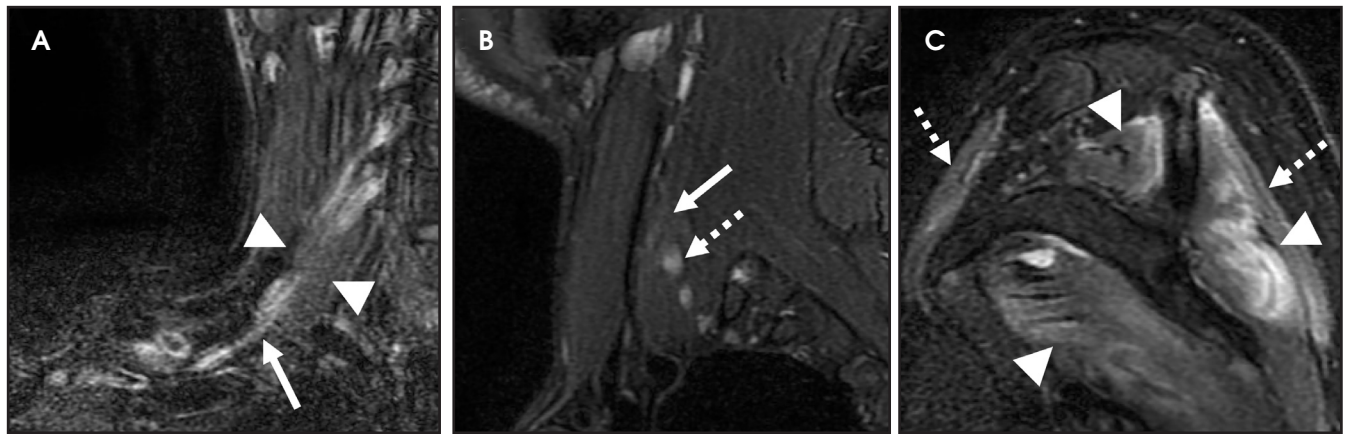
Brachial plexus traumatic postganglionic avulsions in a 39-year-old man following a motorcycle accident. Coronal T2W, fat-saturated MRI (A) of the right brachial plexus shows apparent discontinuity of the postganglionic C5 and C6 nerve roots (between the arrowheads). There is extensive downstream edema within the upper trunk of the right brachial plexus (solid arrow). On sagittal T2W, fat-saturated MRI sequences (B-medial and C-lateral at the shoulder girdle) there is an absence of the C5 nerve root at the expected position compatible with complete avulsion (solid arrow in B), with diffuse enlargement of the C6 nerve root, likely due to severe stretching (dashed arrow in B). Associated denervation edema and atrophy of the right shoulder girdle musculature, including the rotator cuff muscles (arrowheads in C) and deltoid muscle (dashed arrows in C), are seen.
